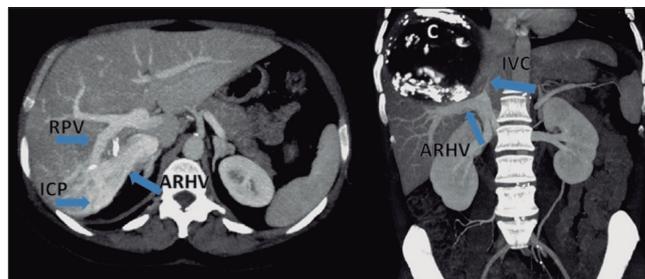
Computed tomography (CT) showing an intrahepatic collateral pathway (ICP) between the accessory right hepatic vein and the right portal vein (RPV: Right portal vein; C: Cyst; ICP: Intrahepatic collateral pathway; IVC: Inferior vena cava).
